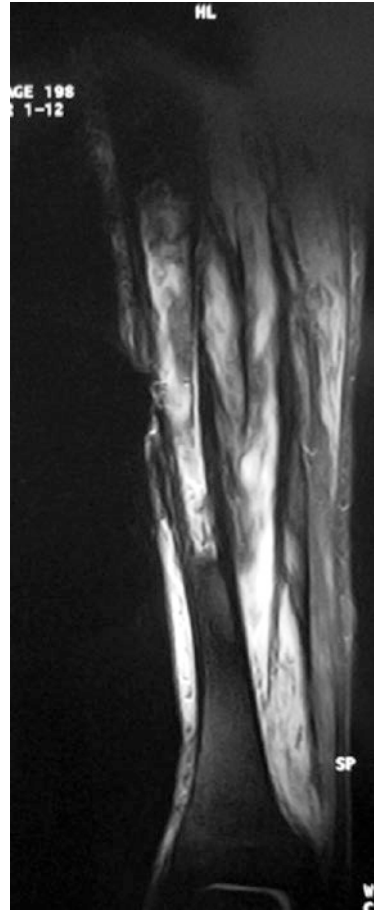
Magnetic resonance imaging study shows the extent of the infection
